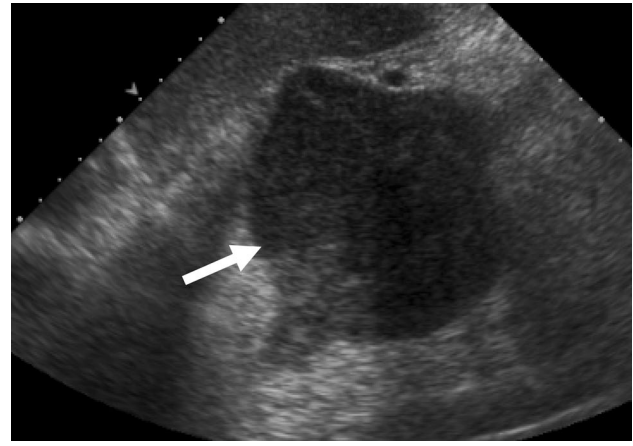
A 69-year-old female patient evaluated for left upper quadrant pain. Abdominal ultrasonography shows a 7 cm solid hypoechoic suprarenal mass (white arrow) that proved to be ACC
